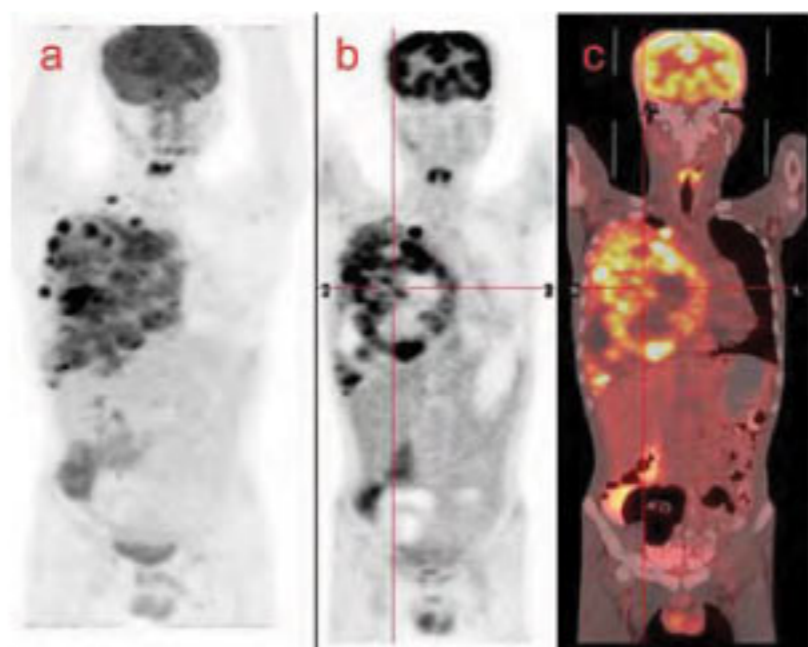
The ^{18}F -FDG images: (a) maximum intensity projection (b) coronal PET and (c) coronal PET/CT showing a large hypermetabolic lesion in the right chest involving entire mediastinum without any other lesion elsewhere in the body.
